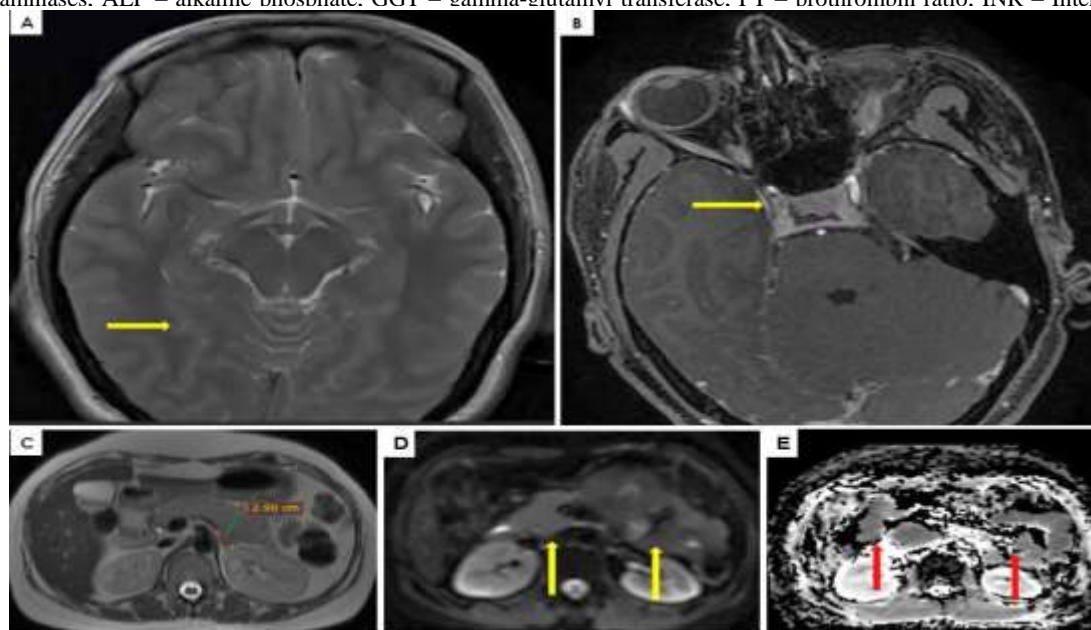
Radioimages of the patient. (A&B) show axial section of contrast-enhanced MRI scan of the brain with ill-defined temporal densities (arrow) and meningeal enhancement (arrow) respectively; (C) shows the axial section of MRCP having bulky pancreas (arrow); (D&E) shows the axial sections of magnetic resonance cholangiopancreatography having diffusion restriction in ADC (arrows) compared to DWI (arrows) respectively.
